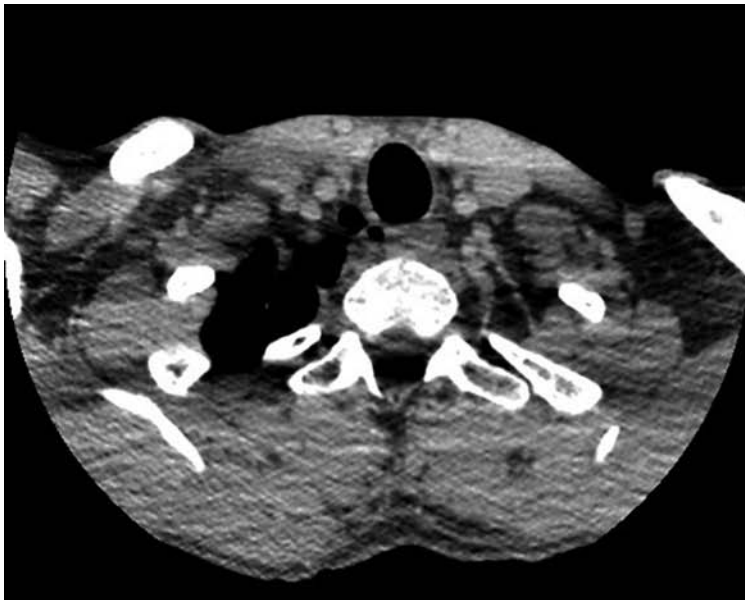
The larynx CT examination
